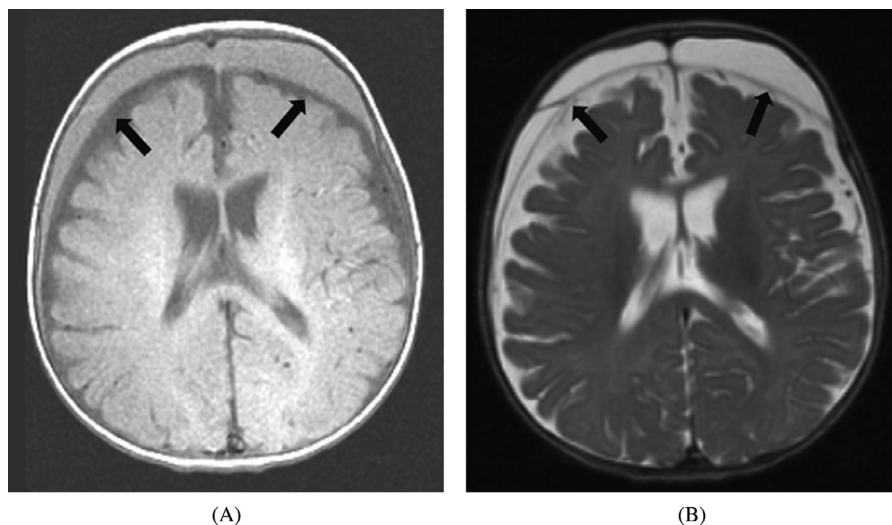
Benign enlargement of the subarachnoid spaces (BESS) with chronic SDH. (A) axial T1, and (B) axial T2 images from a brain MRI examination of a 4 months old male with macrocephaly and otherwise asymptomatic, demonstrate bilateral subdural collections (arrows) and enlarged subarachnoid spaces. The subdural collections were drained and were found to be chronic SDH.
